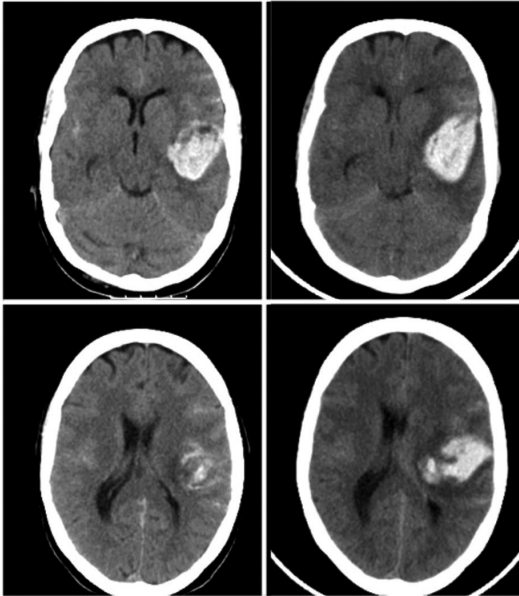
A 48-year-old woman presented to a local hospital with sudden headache, mild right-sided hemiparesis, and dysphasia. She was taking oral anticoagulants because of a history of deep vein thrombosis associated with a factor V Leiden mutation. Non-contrast CT showed an SAH and a left frontotemporal ICH adjacent to the sylvian fissure (left). After normalization of her International Normalized Ratio by administration of a prothrombin complex concentrate, the patient was transferred to our hospital. On admission, her clinical condition was unchanged. A repeat CT scan performed 7 hours after the first CT showed marked ICH expansion with a mass effect (right), and CTA detected a left middle cerebral artery aneurysm without active extravasation. The haematoma was evacuated and the aneurysm was clipped. A year later, the patient's right arm was still paretic, but she had regained independence in daily activities.
